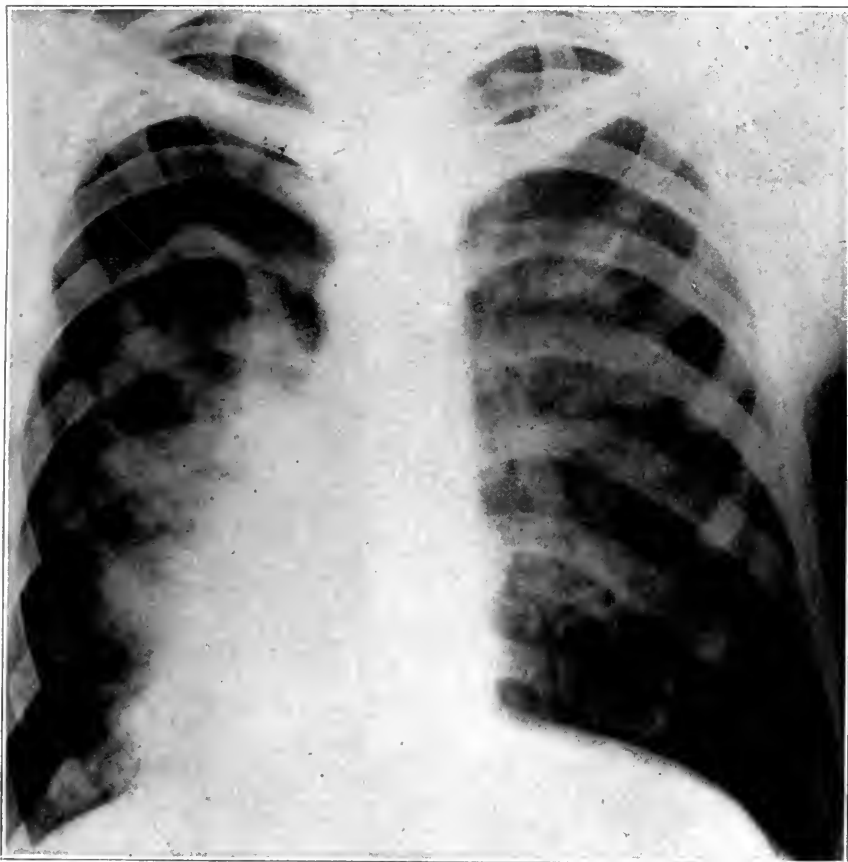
Case 840. Roentgenograms of the lungs in a case demonstrating the difficulty often encountered in making a diagnosis of cavity and annular shadow.
